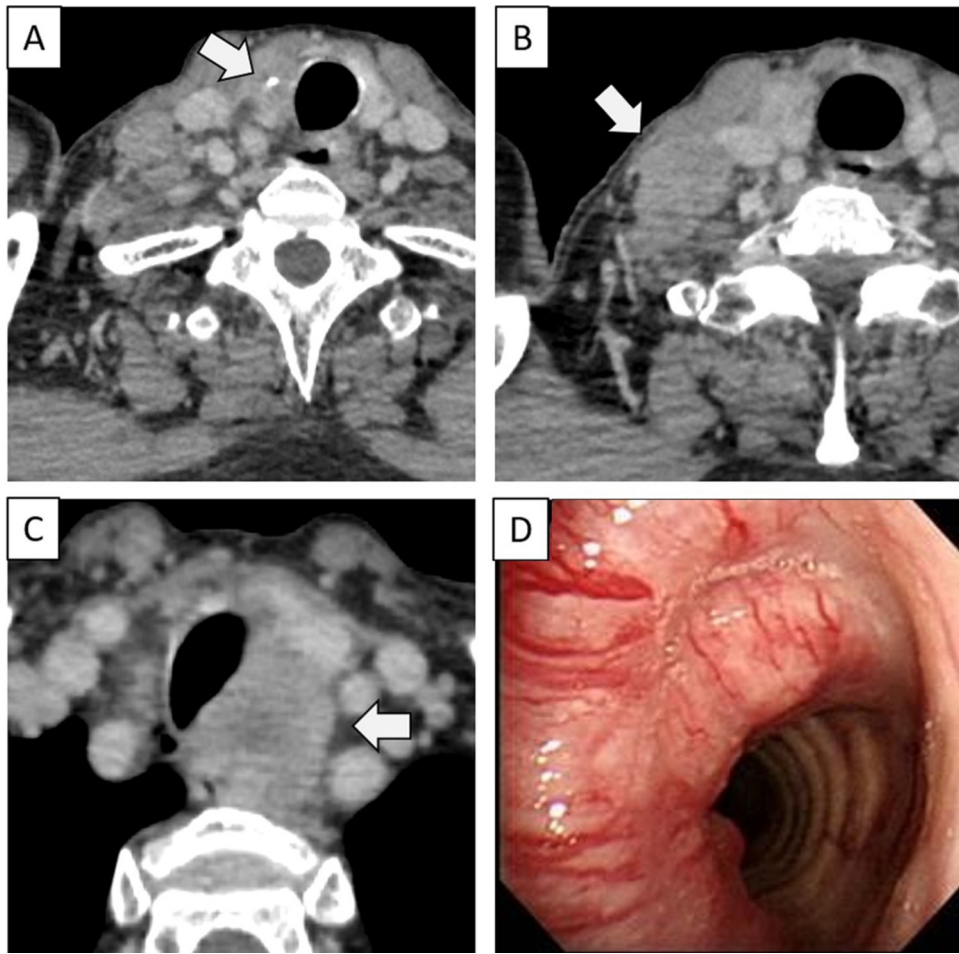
A computed tomography examination revealed a mass, measuring 18 × 17 mm in the upper right lobe of thyroid (A) and swollen lymph nodes in neck: the lymph node at the right upper neck suspected invasion of right internal jugular vein (B), the left paratracheal lymph node suspected invasion of cervical esophagus and trachea (C). Bronchoscope examination revealed tumor invasion in tracheal lumen (D).
